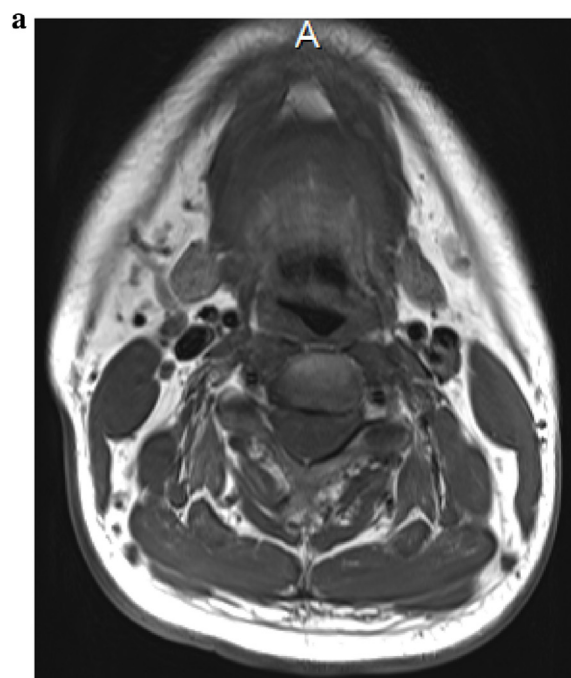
Neither inflammation nor neoplastic lesions were apparent on T1- (a) and T2 (b)-weighted magnetic resonance imaging.
